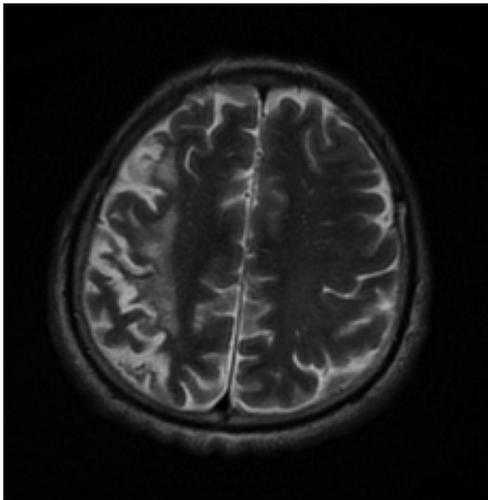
Axial non-contrast T2-weighted MRI reveals unidentified bright objects (UBOs) in cortico-subcortical region of fronto-parietal white matter.
